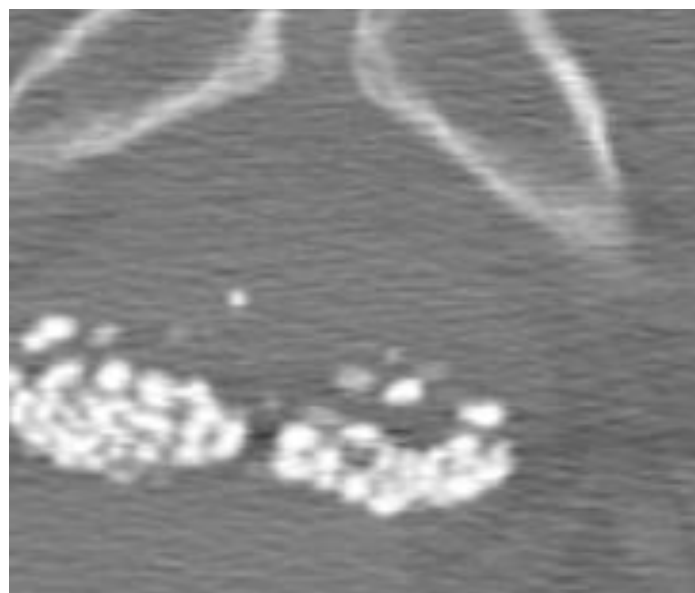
Axial CT scan of the left hip joint of 74-year-old male (2 mm slices) in bone window demonstrate multiple rounded calcifications (calculi) in the posterior aspect of the prostate gland.
